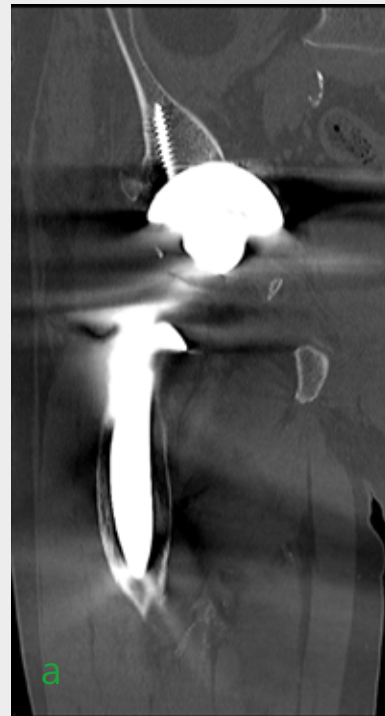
Preoperative CT imaging in the frontal plane (a) and sagittal plane (b, c), acetabular defect situation.
